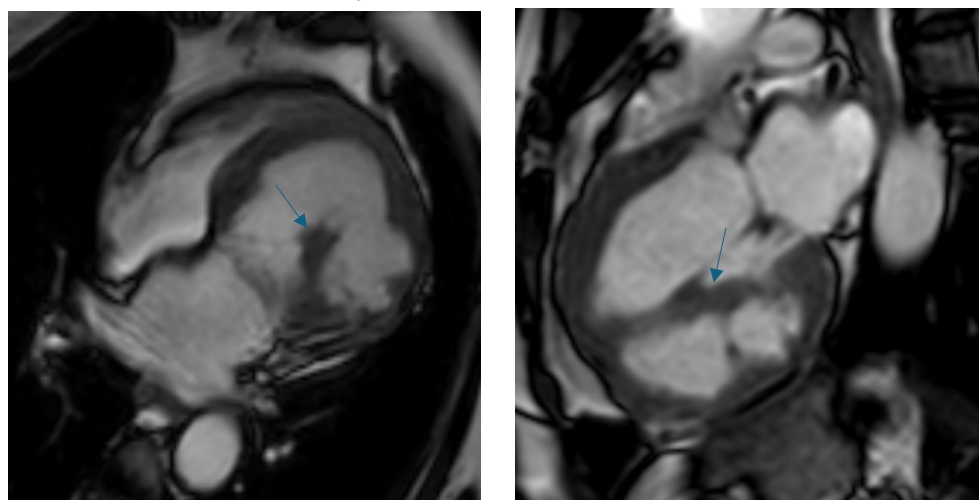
Case 1 (50-year-old male with DCLV and distal fibrosis): Cardiac MRI demonstrating fibromuscular ridge in apical cavity with rare subendocardial fibrosis. (a) 4-chamber cine view showing muscular ridge (straight arrows) dividing LV into compartments; (b) Short-axis cine demonstrating ridge anatomy; (c) Late gadolinium enhancement short-axis view showing subendocardial enhancement (straight arrows) in distal chamber, consistent with localized fibrosis (3% scar burden).
